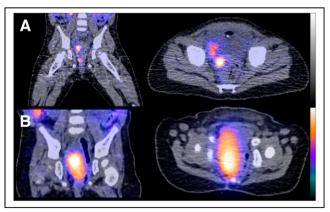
Improved spatial and contrast resolution of pelvic lesions on coronal (left) and axial (right) ⁶⁸Ga-DOTATATE PET/CT (A) compared with MIBG SPECT/CT (B).
